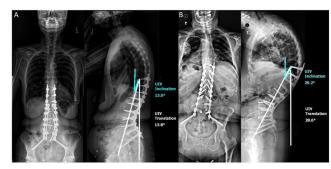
Anteroposterior and Lateral standing radiographs of patients A) in G1 and B) in G2
